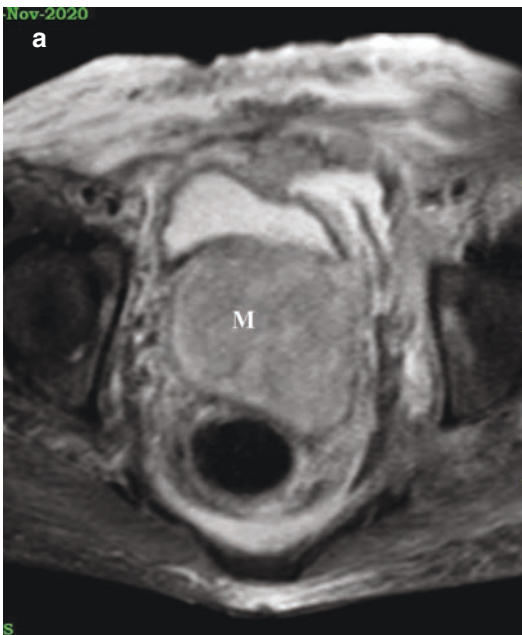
Cervical cancer (M) with parametrial invasion and enlarged iliac node. (a) T2 axial MRI showing a bulky cervical mass. (b) T1 contrast axial MRI showing cervical mass infiltrating bilateral parametrium (more on the left) (horizontal white arrow) with enlarged left iliac
